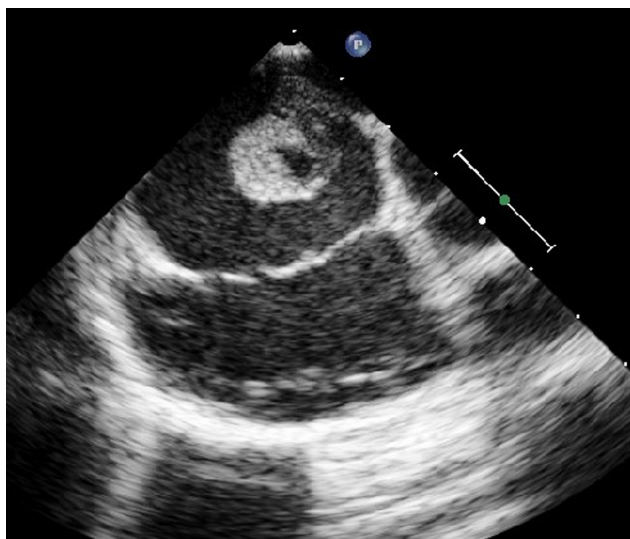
Transesophageal echocardiography showing an echo-dense pedunculated mass attached to the atrial septum.
